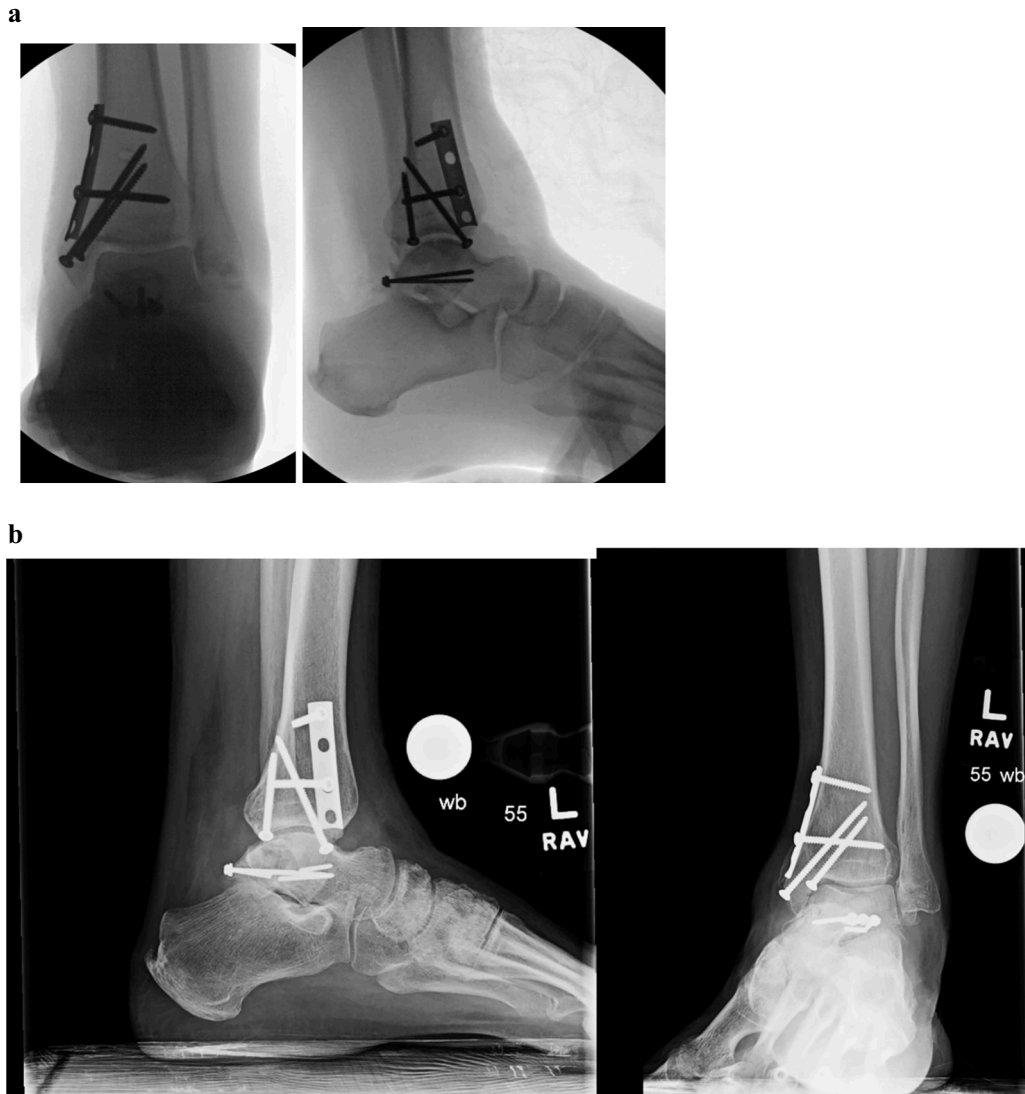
a Representative intraoperative fluoroscopic AP (left) and lateral (right) images demonstrating reduction and fixation, b Postoperative radiographs at 1 year postoperative demonstrating posterior talar collapse and broken screws.
